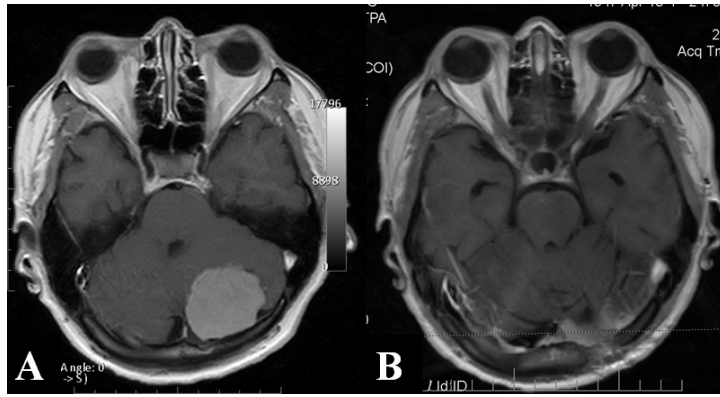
(Case 2) Preoperative (A) and postoperative (B) axial T1-weighted images with contrast of a left transverse sinus meningioma
